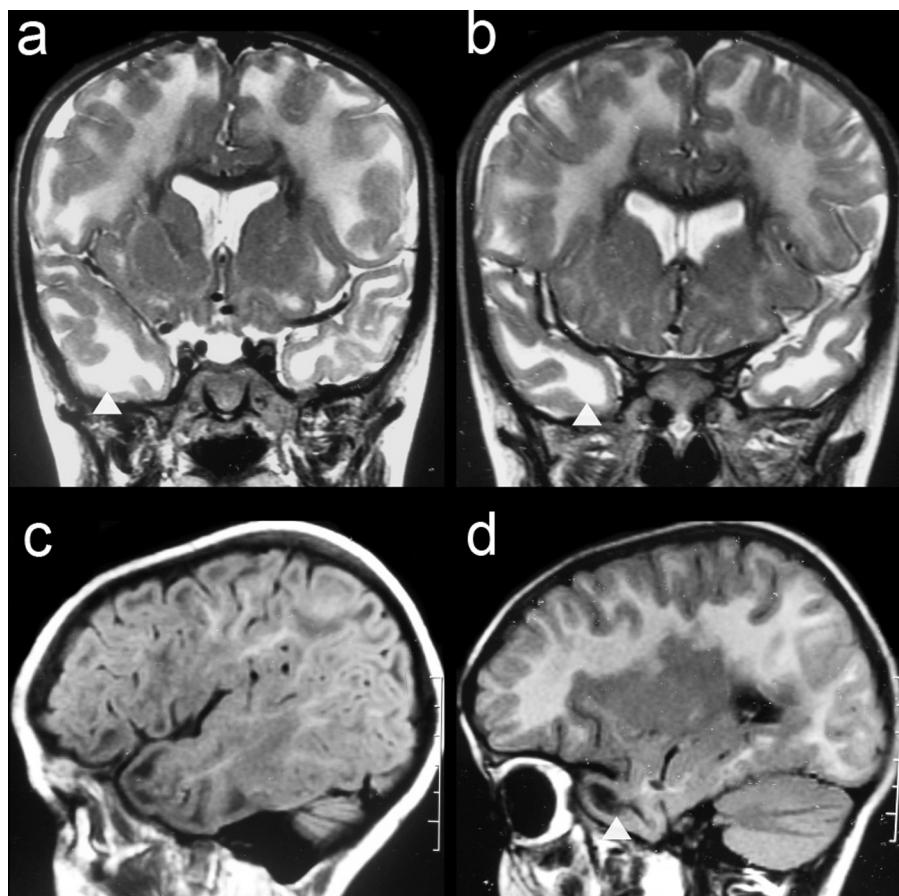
Coronal T2 FSE weighted images (a and b) and sagittal T2 FLAIR weighted images (c and d), showing WM abnormalities with WM swelling in frontal lobes (a and b). Some of signal abnormalities present a hypointensity in T2 FLAIR sequence (figures c and d: WM rarefaction).
